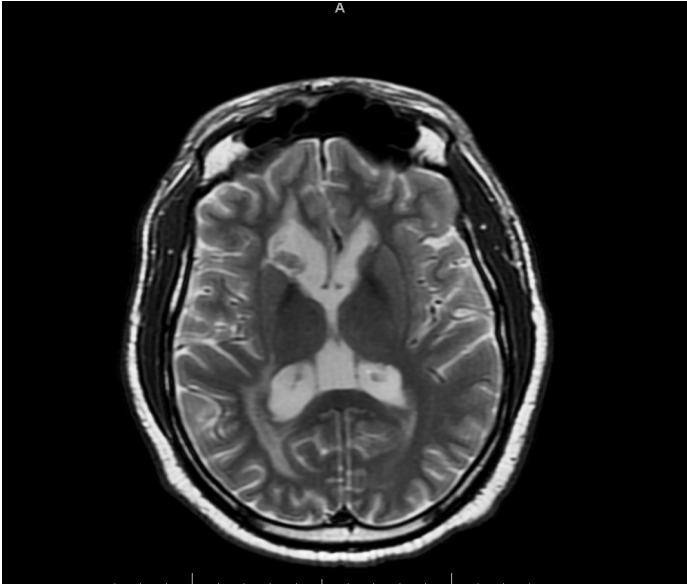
Brain MRI Post treatment with WBRT (T2 axial image) showing abnormal signal changes in right caudate nucleus, the right genu of the corpus callosum and periventricular white matter, which are significantly improved since prior study and smaller in size. Additionally, mild dilatation of the right frontal horn is noted.
